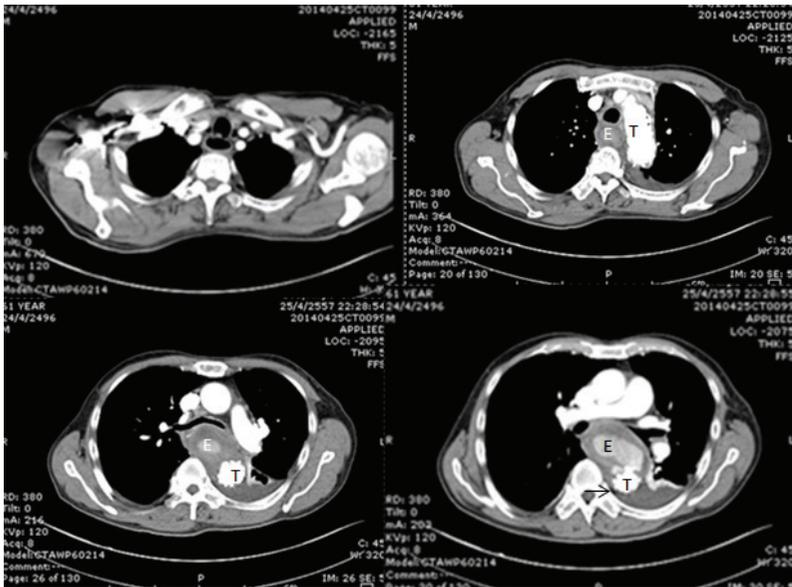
CT scans of a thoracic aortic aneurysm after thoracic endovascular stent procedure, showing a periendovascular stent air bubble that suggests a persistent aorto-esophageal fistula. The arrow identifies an air bubble around the stent. E: esophagus, T: thoracic aorta.
